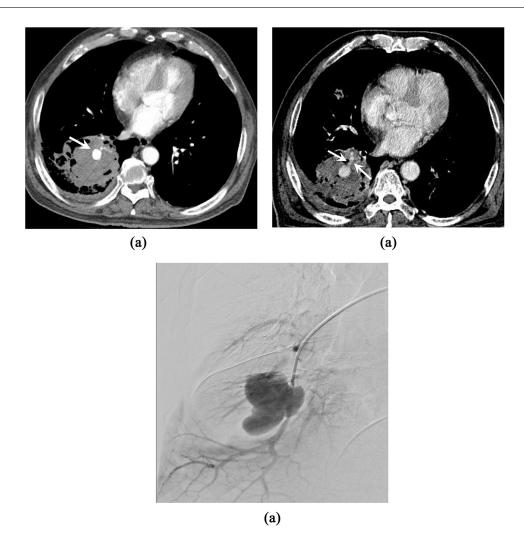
Chest computed tomography (CT) scans in a 64-year-old man with pulmonary artery pseudoaneurysm. (A) A 1.5 cm contrast media filling sac (arrow) seen in the right lower lobe, probably arising from the right lower lobar pulmonary artery. (B) Chest CT scan obtained on the sixth day of hospitalization for the planning of the radiation therapy shows interval increase in the pseudoaneurysm. Note the aneurysmal neck (arrows) arising from the right lower lobar pulmonary artery. (C) Conventional angiography with selection of the right lower lobar pulmonary artery demonstrates a lobulated pseudoaneurysm arising from the right lower lobar artery. CT, computed tomography.
